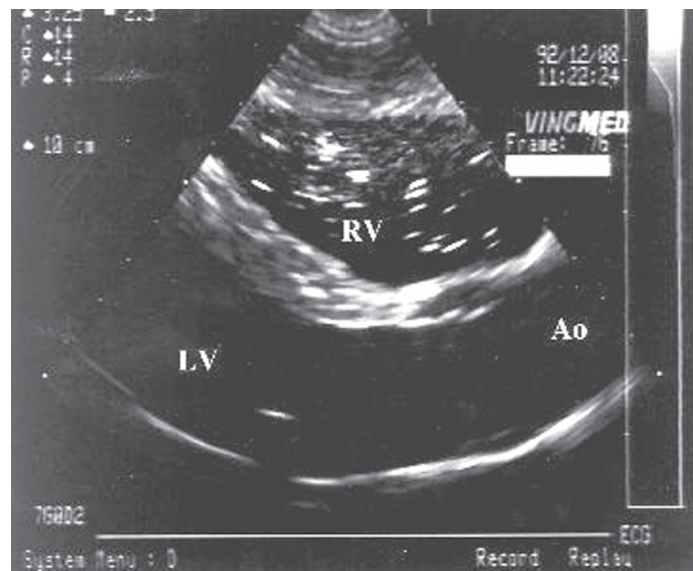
Ultrasound image showing multiple gas bubbles in the right ventricle (RV) and one gas bubble in the left ventricle (LV). Ao – Aorta. The diver was later shown to have a patent foramen ovale.
